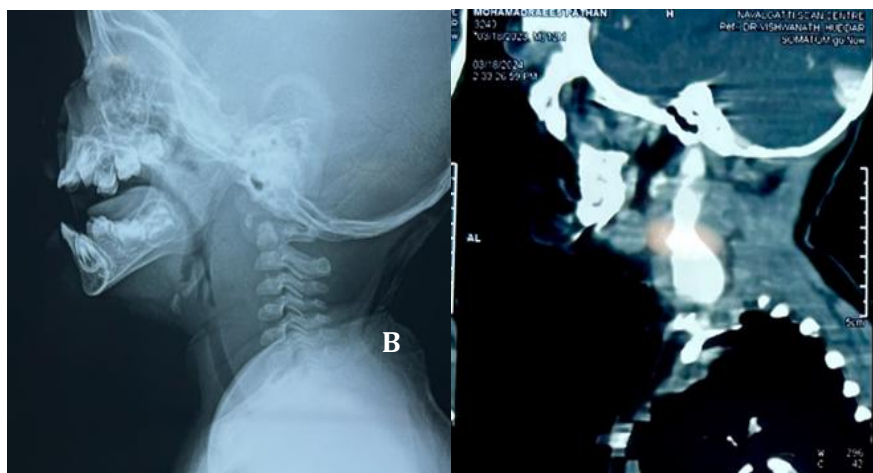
Lateral X-ray of the neck
